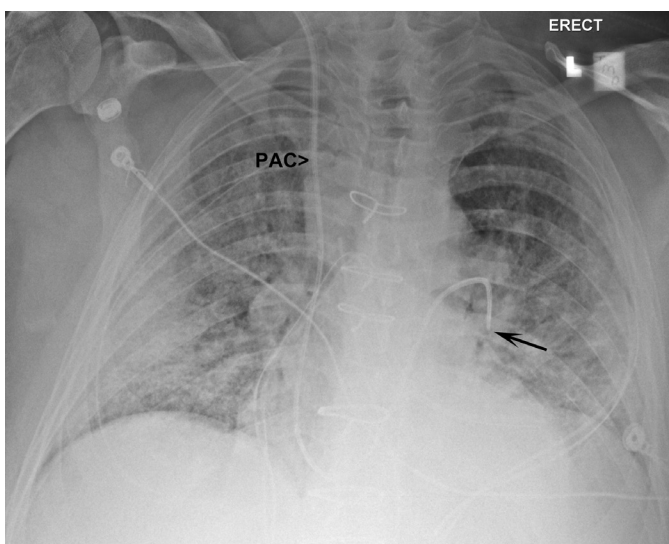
■ Anteroposterior (AP) upright chest x-ray. Swan-Ganz catheter tip (*arrow*) is too distal, located in left lower lobe pulmonary artery. Background of cardiomegaly, interstitial and alveolar edema, and retrocardiac atelectasis.
